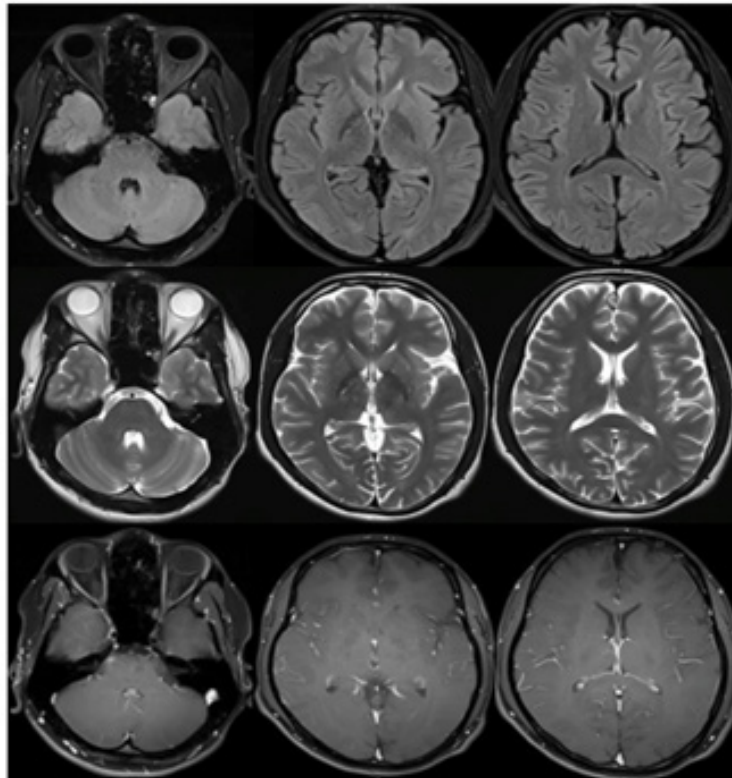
MRI brain axial images, FLAIR sequence (top row), T2 sequence (middle row) and T1 gadolinium enhanced (bottom row) showed no intra-parenchymal plaque and no abnormal enhancement to implicate demyelination.
